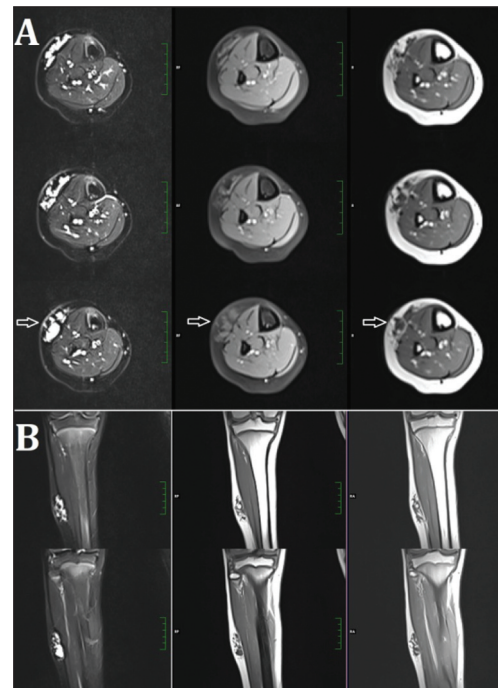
Fat saturated T2 weighted (left column), fat-saturated T1 weighted (middle column), and contrast-enhanced T1 weighted (right column) magnetic resonance images of the same axial planes are shown. The vascular lesion was observed in the middle crural level, located in the subcutaneous fat planes (A). Coronal plane magnetic resonance images of the same patient. Fat saturated T2 weighted (left column), fat-saturated T1 weighted (middle column), and contrast-enhanced T1 weighted (right column) magnetic resonance images of the same coronal levels are shown. The vascular lesion was observed in the middle crural level, located in the subcutaneous fat planes (B).
